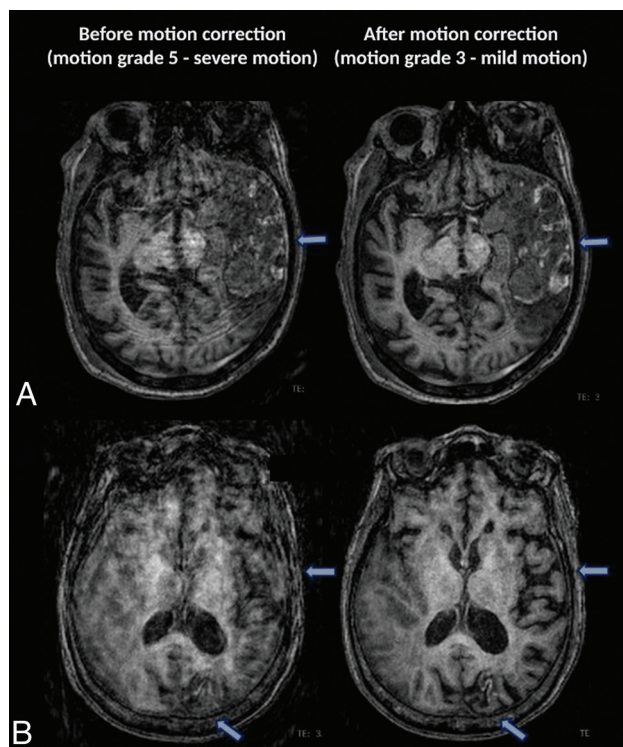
Axial MR images of 2 cases with severe motion artifacts (grade 5) in which SAMER motion correction restored diagnostic value (by reducing motion grade to 3). *A*, The extent of cortical/gyral enhancement (arrows) and edematous expansion of the left temporoparietal region with a mild rightward mass effect is better visualized on the motion-corrected image of a 67-year-old man with traumatic brain injury. *B*, Motion-corrected image shows better visualization of cortical laminar necrosis in the left occipital lobe (arrows) and better evaluation of left temporal lobe volume loss (arrows) in an 86-year-old woman with history of stroke.
